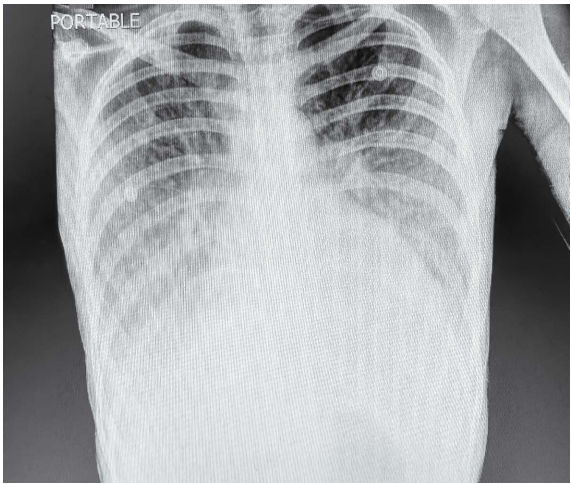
Antero-posterior radiograph of the chest showing peribronchial cuffing and perihilar haze, along with septal (Kerley) lines.
